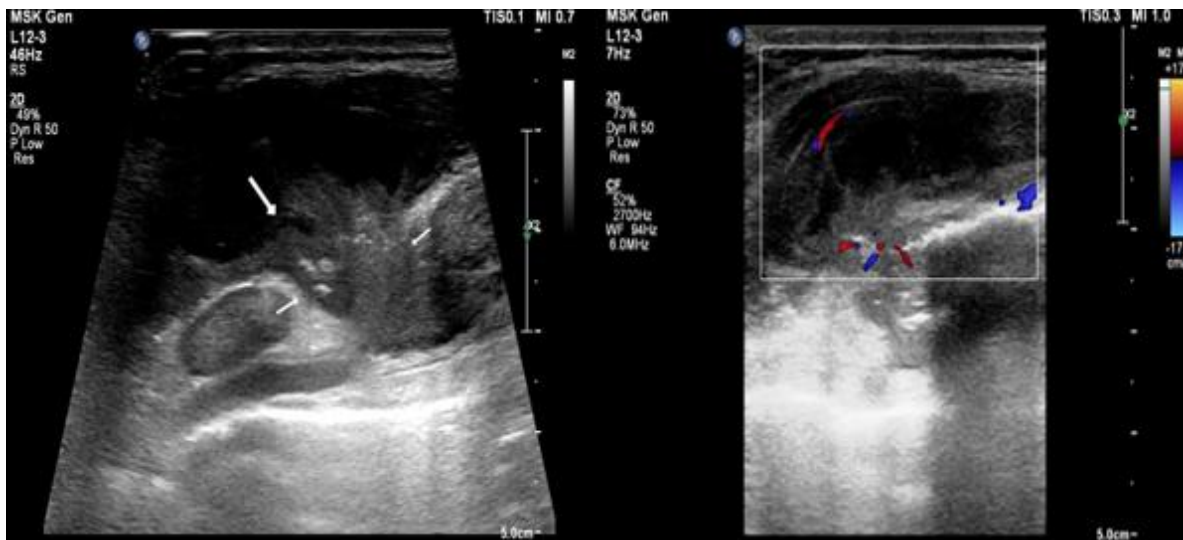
(Left) – Ultrasonographic examination of the chest wall swelling revealed an ill-defined, hypoechoic collection in the subcutaneous plane. The underlying bone was lytic and the collection was seen extending posteriorly through the underlying bone abnormality, into the retrosternal compartment (white arrows).
